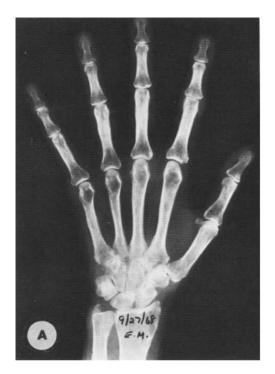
Oblique roentgenograms of both hands of patient EF obtained 21 months after local treatment of right hand and wrist joint with triamcinolone hexacetonide. Destruction of bony and cartilaginous structures has occurred on both sides, although changes are more extensive on the untreated side. Soft tissue calcification is visible near the right ulnar styloid. Films obtained at the time of treatment showed only soft tissue swelling and are therefore not reproduced here.
